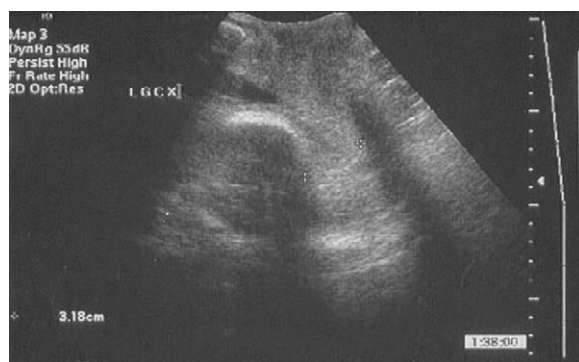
Transabdominal view of the cervix. The fetal head precludes adequate visualization of the cervix. Visualization of the cervix with transabdominal ultrasound is technically more difficult than with transvaginal ultrasound.
